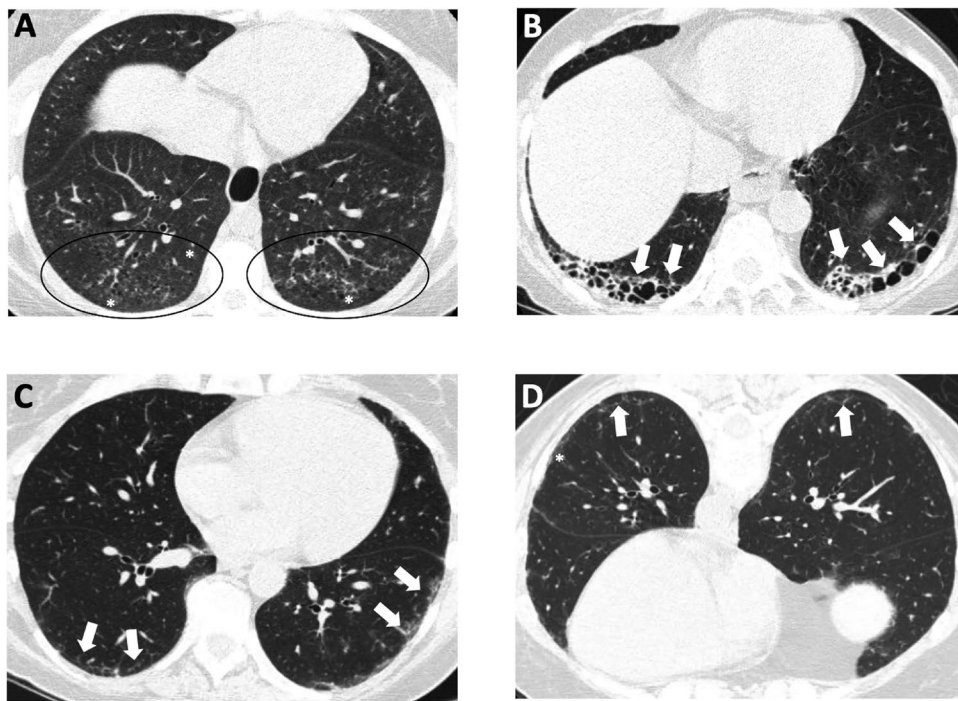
High-resolution computed tomography images of the lungs of 3 different patients with systemic sclerosis (SSc)-related interstitial lung disease (ILD). A, Nonspecific interstitial pneumonitis (NSIP) with a lower lobe subpleural predominant distribution of primarily ground-glass opacity (asterisks and encircled areas). B, Definite usual interstitial pneumonitis with subpleural lower lobe honeycombing (arrows). C and D, Mild ILD on the supine image (arrows) (C), which could be interpreted as dependent atelectasis; however, it persists on the prone image (D), confirming the presence of ILD. The pattern of septal thickening (arrows) and ground-glass opacity (asterisk) without bronchiectasis is most consistent with NSIP in a patient with SSc.
